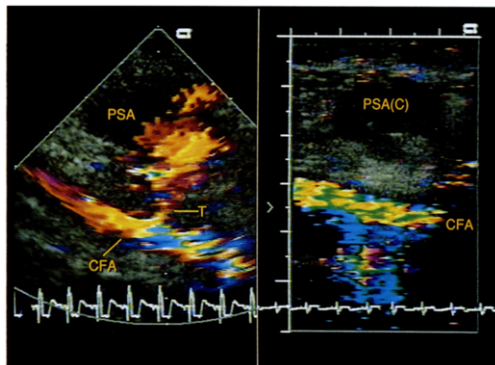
Patient 2. Doppler color flow ultrasound study of nonsurgical closure of a femoral artery pseudoaneurysm after coronary angioplasty and stenting. Left panel, Precompression study. The long-axis view systolic frame shows a tract (T) connecting the right common femoral artery (CFA) with the cavity of a large pseudoaneurysm (PSA). Right panel, Postcompression study. The tract is completely obliterated and no flow signals are apparent within the pseudoaneurysm, indicating pseudoaneurysm closure (PSA [C]).
